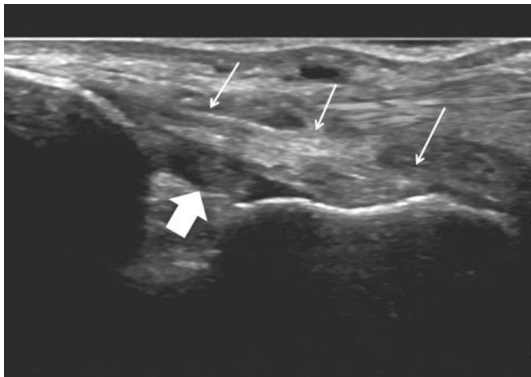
Sonographic image of the medial submalleolar region (coronal-oblique plane, panoramic view): the fasciculi that make up the medial collateral ligament are clearly visualized: the superficial layer (thin arrows) and the deep layer (thick arrow) at the tibiotalar level, which appears hypoechoic owing to anisotropy
